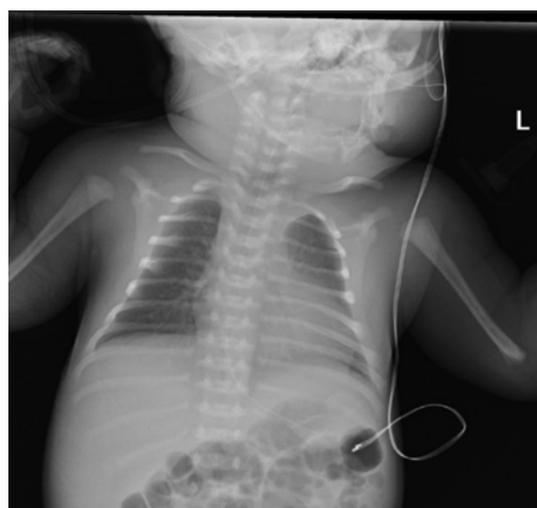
Chest X-ray compatible with RDS
